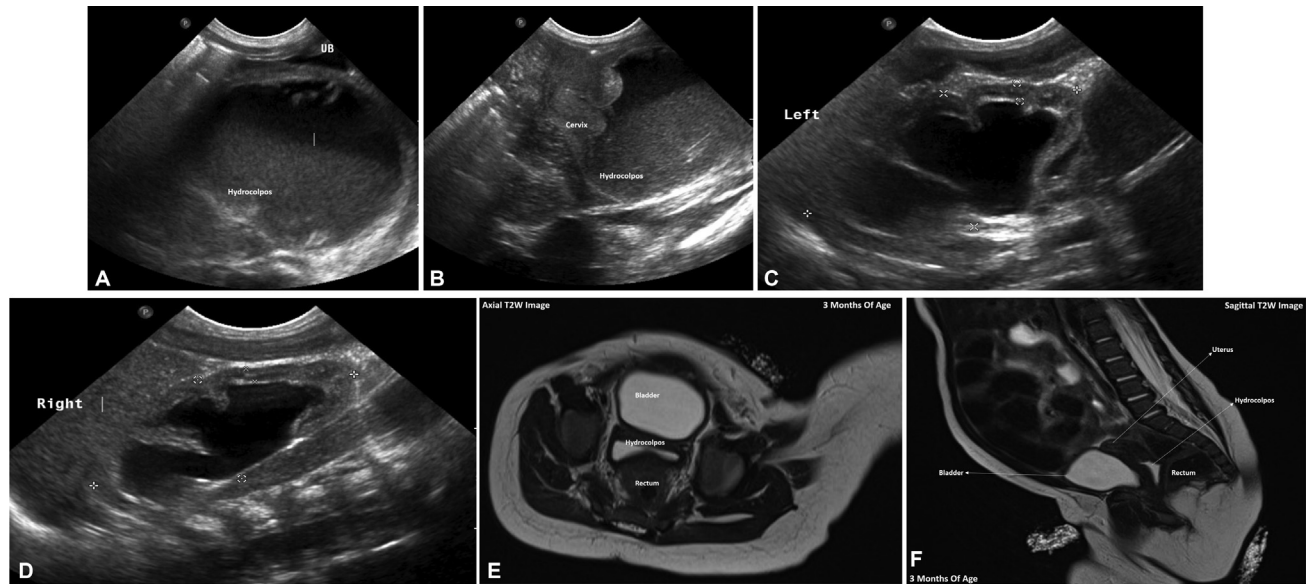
(A) Postnatal ultrasound of neonate showing markedly dilated vagina containing thick echogenic fluid measuring 9 cm × 6 cm × 4 cm displacing the bladder upward anteriorly. (B) Postnatal ultrasound of neonate showing markedly dilated vagina containing thick echogenic fluid showing in relation with cervix. (C, D) Postnatal ultrasound of neonate showing bilateral pelvic/cecal dilatation. (E) Postnatal follow-up magnetic resonance imaging (MRI) axial T2-weighted (T2W) image of neonate showing residual collection between the bladder and the rectum. (F) Postnatal follow-up magnetic resonance imaging (MRI) sagittal T2W image of neonate showing residual collection between the bladder and the rectum.
